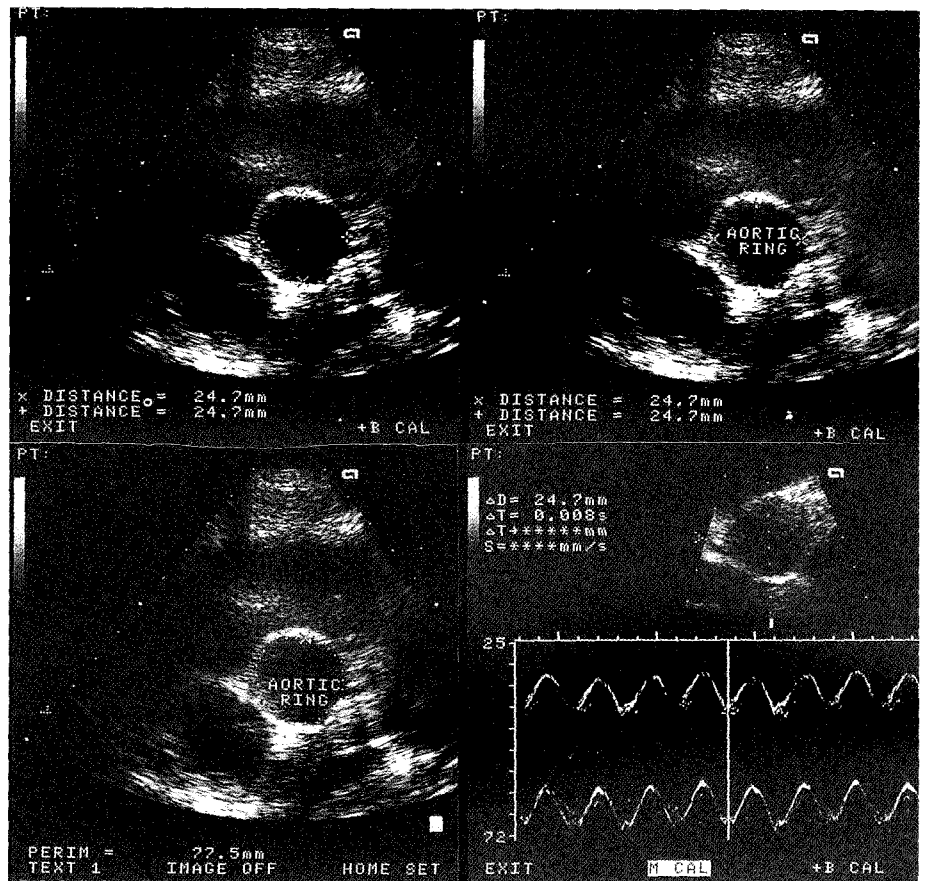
Method of visualization and measurement of the diameter and the circumference of the aortic rings examined using echocardiography.
